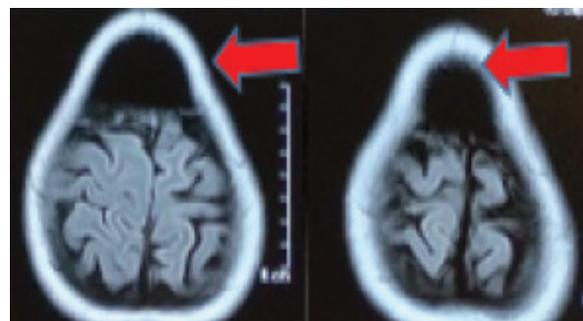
Magnetic resonance imaging FLAIR axial images showing expansile hypointense lesion in diploic space of fronto-parietal bone
